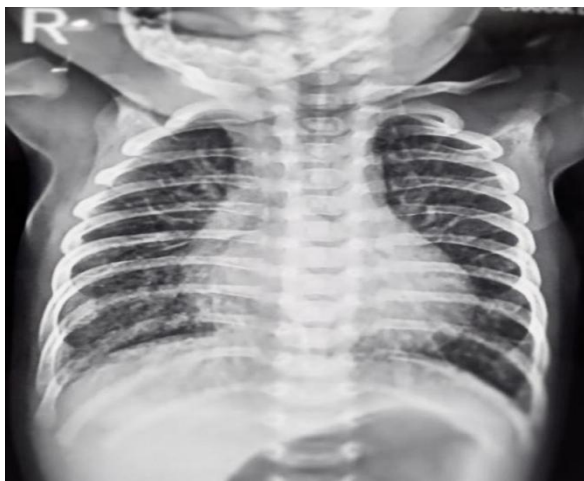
X-ray chest AP view indicates obvious cardiomegaly with severe pulmonary venous congestion.
